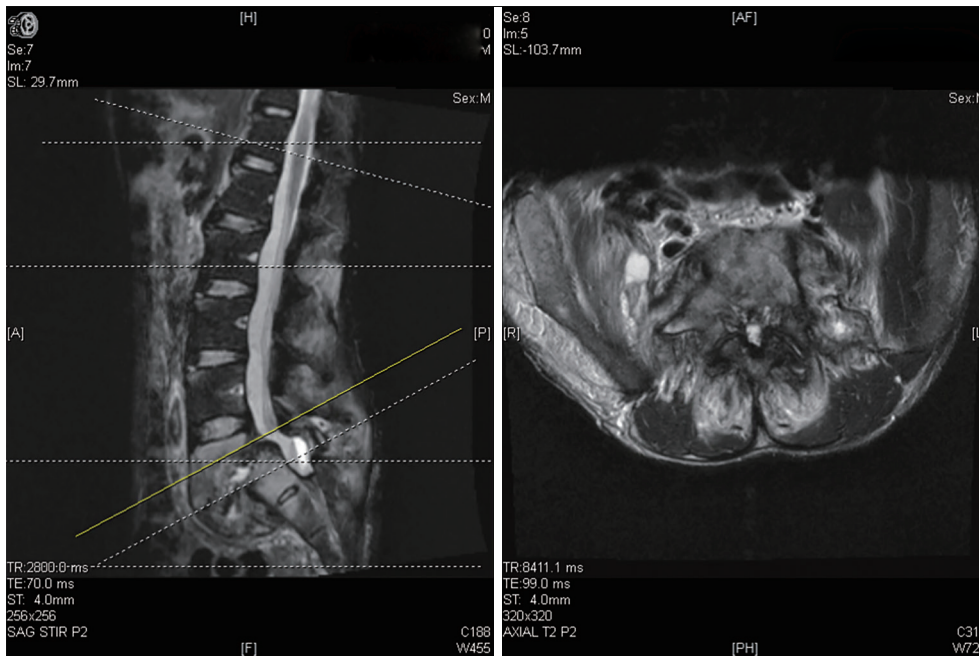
T2-weighted MRI imaging of lumbar spine (L5-S1) on presentation. MRI, magnetic resonance imaging; TR, repetition time; TE, echo time.
